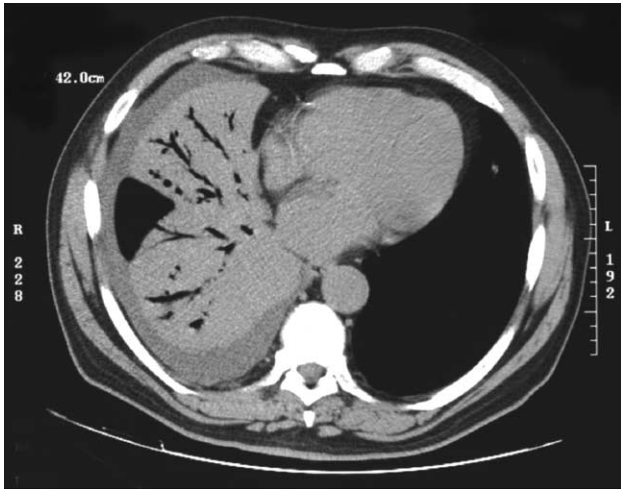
Air-space consolidations: CT scan shows air-space consolidation with air bronchograms involving right middle and right lower lobe. Small adjacent pleural effusion is present.
